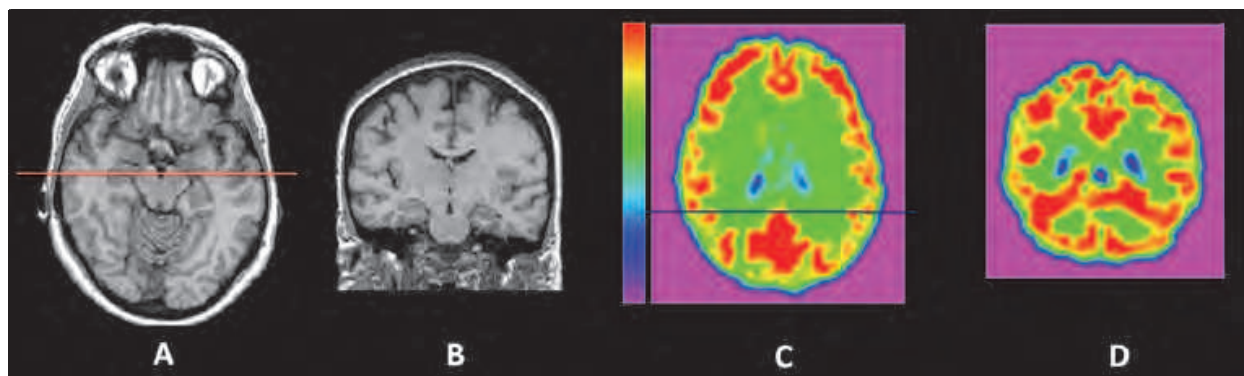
Brain MRI and perfusion SPECT images of a clinically healthy subject (female, age= 64 years, MMSE=30). A) to D) are similar images show in figure 1.
